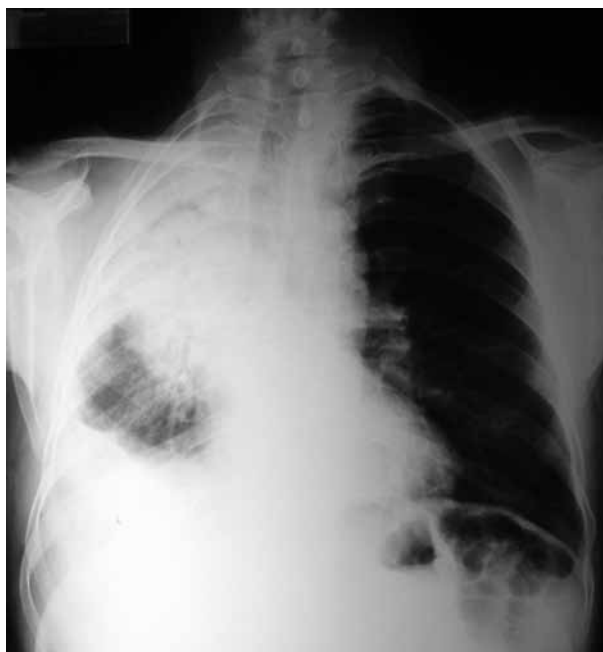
Chest X-ray graphy showing pleurisy and lack of aeration on the right upper and middle lobes.
